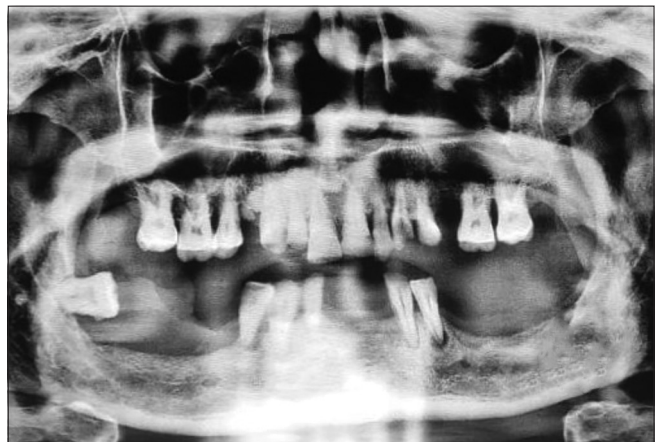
Orthopantomogram showing horizontally placed right side mandibular third molar, missing bilateral mandibular molars and periodontally compromised remaining dentition
